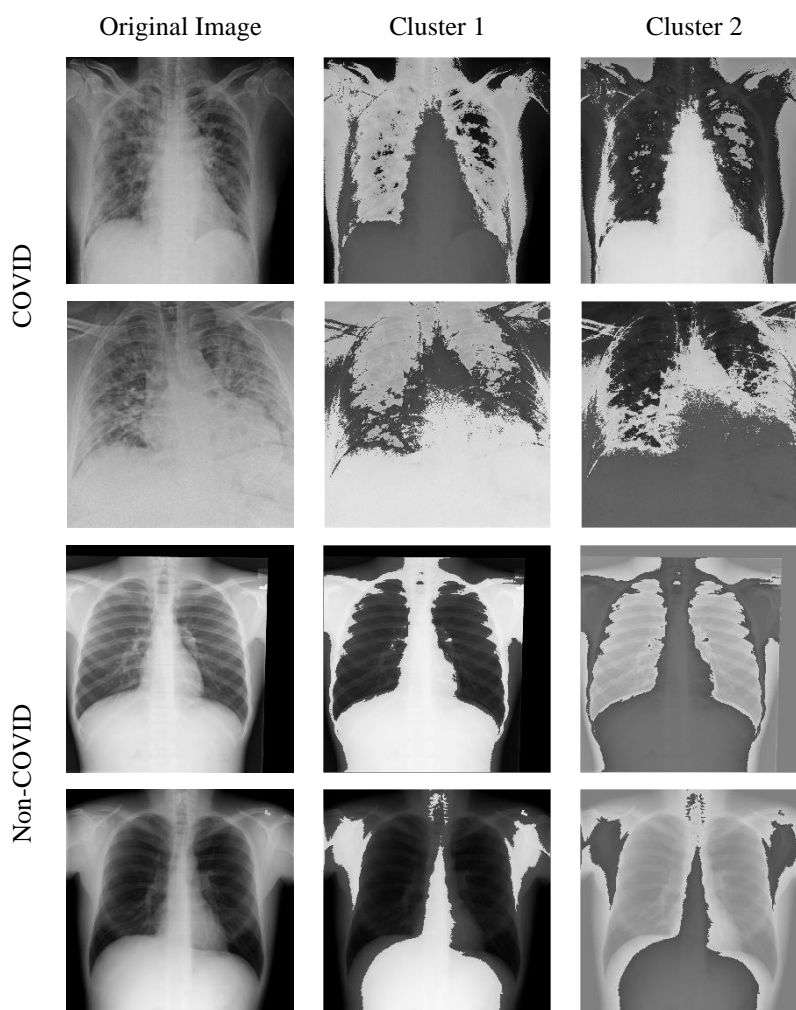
Sample segmented X-ray images with the k-means method
